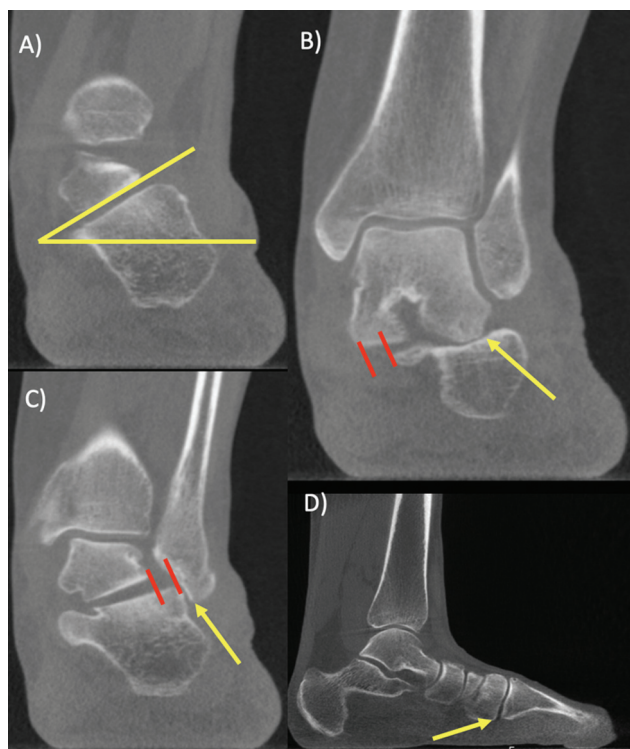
Coronal weight-bearing computed tomography scan demonstrating: (A) the misalignment of the subtalar joint; (B) sinus tarsi impingement and medial facet subluxation; and (C) subfibular impingement and posterior facet subluxation. (D) Sagittal scan demonstrating instability with the plantar opening of the tarsometatarsal joint.
